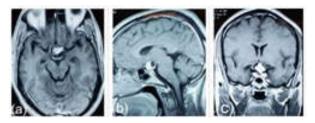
(a) (b) (c) MRI brain shows Craniopharyngioma with solid and small cystic component.
